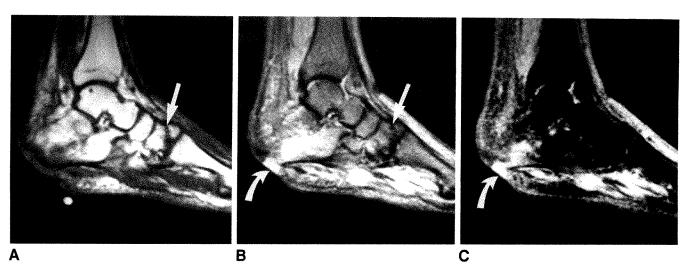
Old fracture and osteomyelitis of calcaneus with sinus tract in 38-year-old man. Abnormal calcaneus signal is shown on T1-weighted (583/20) (A), T2-weighted (2000/100) (B), and short-tau inversion recovery (2000/125) (C) images. Note sinus tract (curved arrow) extending from open wound into calcaneus. An old fracture (straight arrow), presumably due to peripheral neuropathy, shows normal bone-marrow signal in bony fragments on all pulse sequences.
